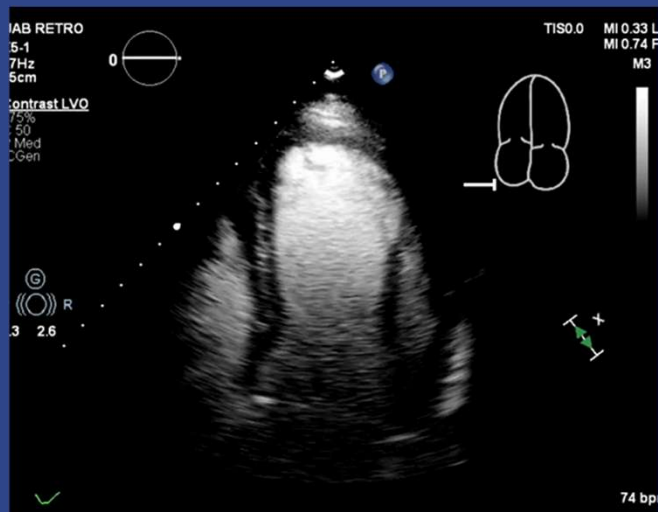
Cine GIF apical four UEA image from author's clinical collection, de-identified (M.Trump, 2025)
